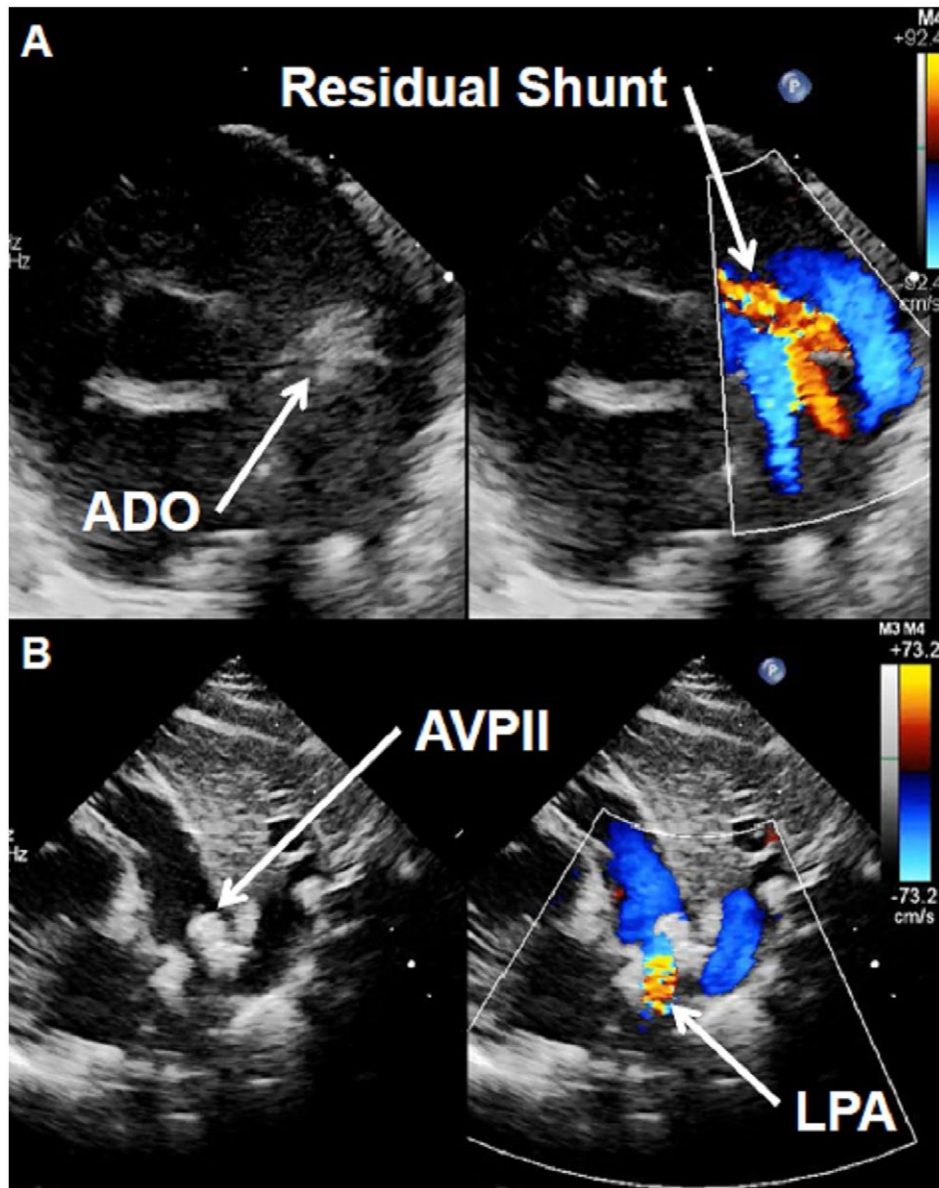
High left parasternal transthoracic echocardiogram color compare Doppler of different complications of transcatheter PDA device closure. A, Residual left to right shunt after initial placement of an Amplatzer Duct Occluder (ADO). B, Left pulmonary artery (LPA) stenosis after initial placement of an Amplatzer Vascular Plug II (AVPII). Both devices were repositioned with no residual shunting or obstruction
